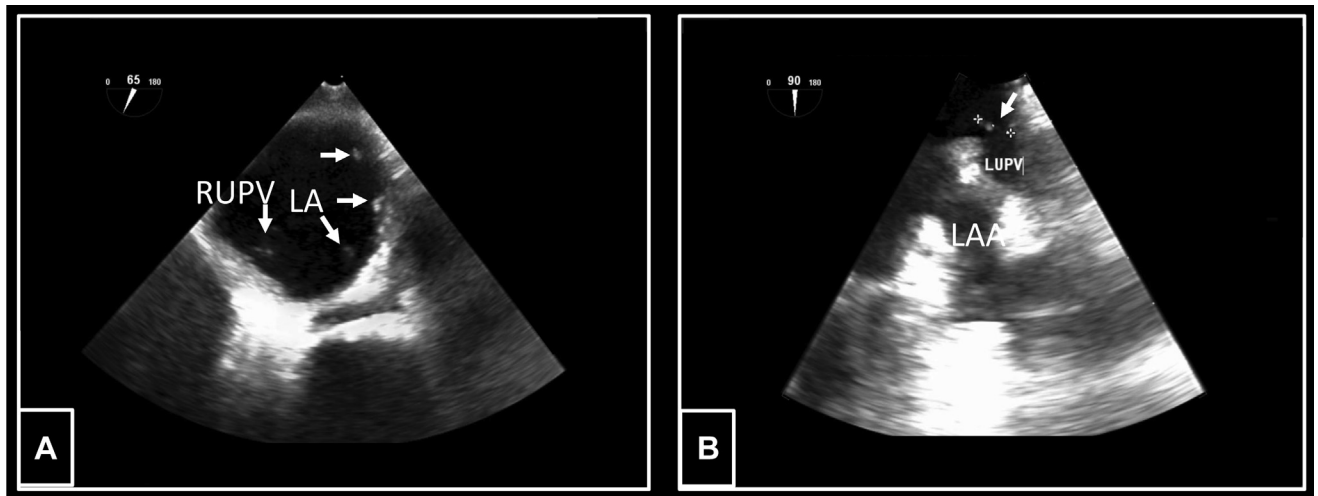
TEE-2. A: Despite switching oral anticoagulation from rivaroxaban to therapeutic warfarin with goal international normalized ratio 2.0–3.0, transesophageal echocardiography (TEE)-2 demonstrated persistence of multiple left atrial thrombi (white arrows). B: TEE-2 showing fixed left atrial thrombus at the ostium of the left upper pulmonary vein (LUPV) (white arrow). LA = left atrium; LAA = left atrial appendage; RUPV = right upper pulmonary vein.
